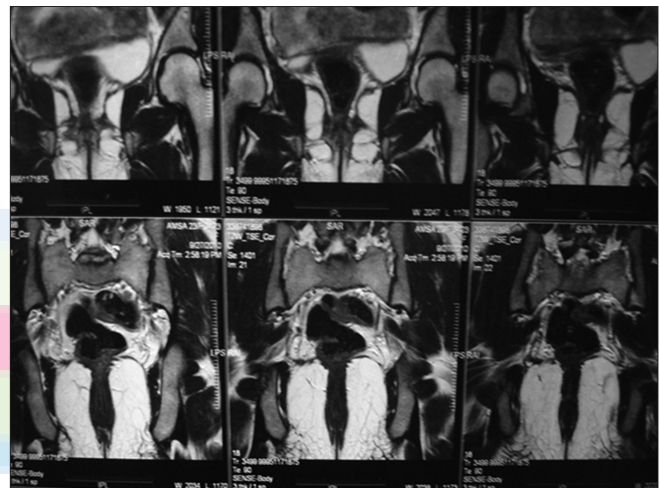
Magnetic resonance imaging abdomen - Visualization of gonads with features s/o of ovary at both para iliac region
